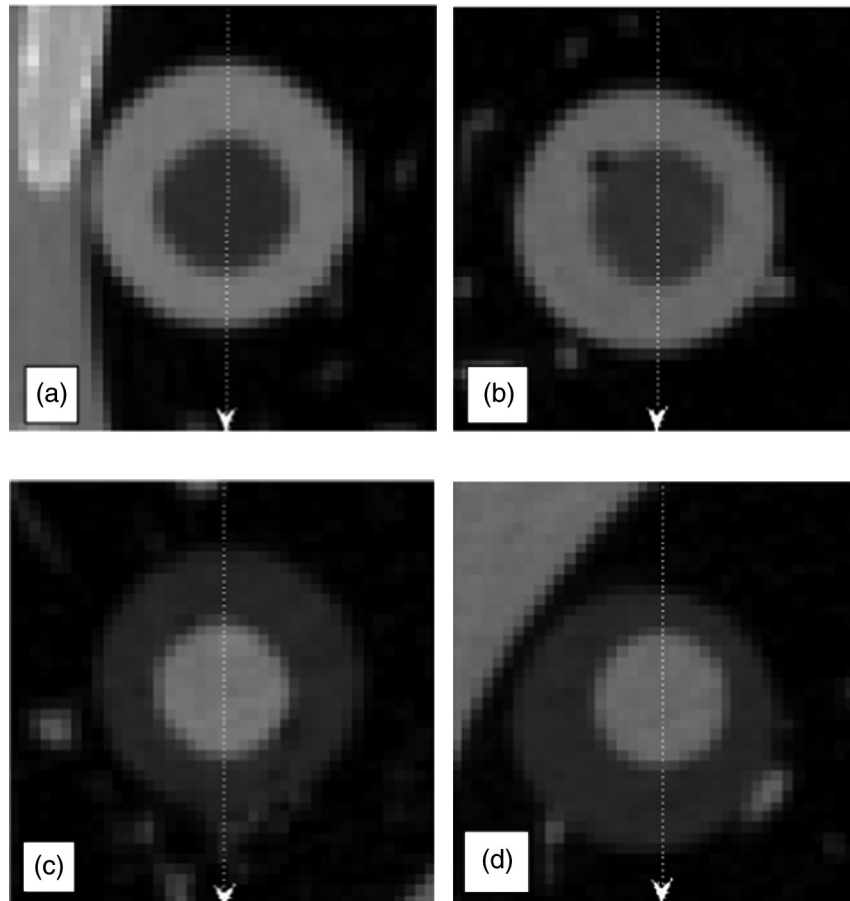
Regions of interest (ROI) from CT scans of the multidensity nodules with outer/inner shell diameters of 20/10 mm and outer/inner shell HU values of (a) 100/−630, (b) 10/−630 HU, (c) −630/100 HU, and (d) −630/−10 HU. These ROIs were extracted from scans acquired with 120 kVp, 100 mAs, 1.2 pitch, 16×0.65 mm slice collimation, and reconstructed with 0.75 mm slice thickness and a b40f reconstruction kernel. In addition to the four nodules shown here, the study utilized four nodules with corresponding HU values but outer/inner shell diameters of 10/5 mm. Note that due to the manufacturing process the spheres are not exactly concentric.
